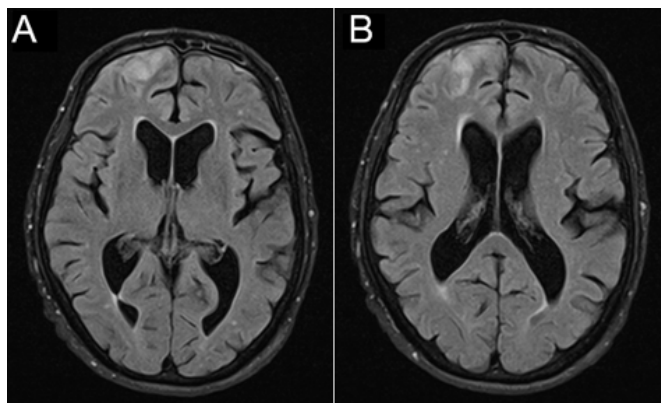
Axial fluid-attenuated inversion recovery MRI brain images demonstrated cortical hyperintensity in the frontal lobes, more prominent on the right. There was modest bilateral frontal intraparenchymal and leptomeningeal contrast enhancement (not shown).
